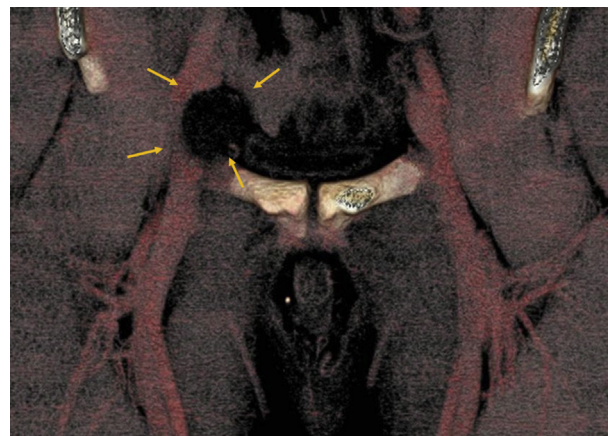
Computed tomography angiography scan showing the presence of an oval mass with definite borders containing homogeneous fluid and determining a relevant stenosis of the external iliac vein (EIV).
